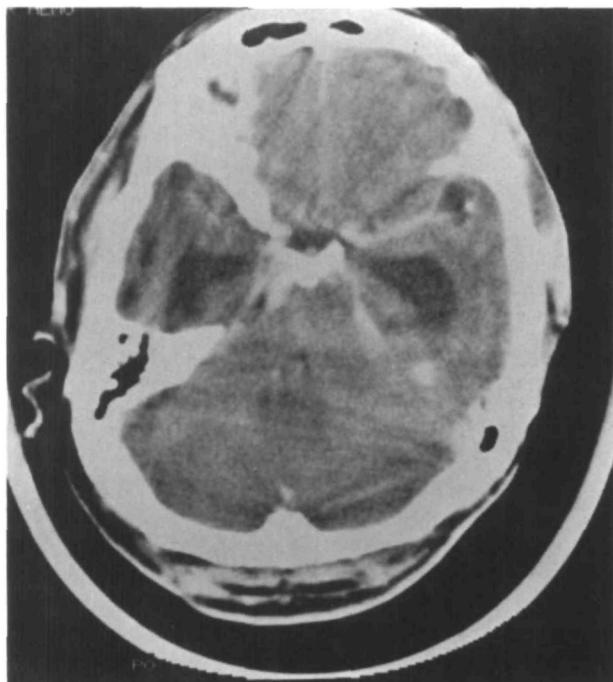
Computed tomogram showing low attenuation in bilateral cerebellar hemispheres with compression of fourth ventricle and hydrocephalus in case 9 on second day of admission.
